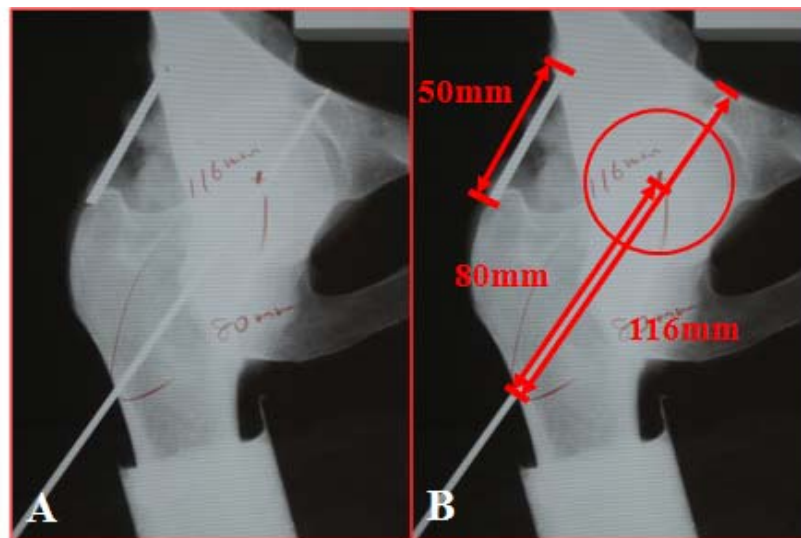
X-ray of the hemi-pelvis (A). The annotated radiograph (B) reveals that the K wire was indeed appropriately placed, and shows measurements of the effective neck length and distance between joint members.
